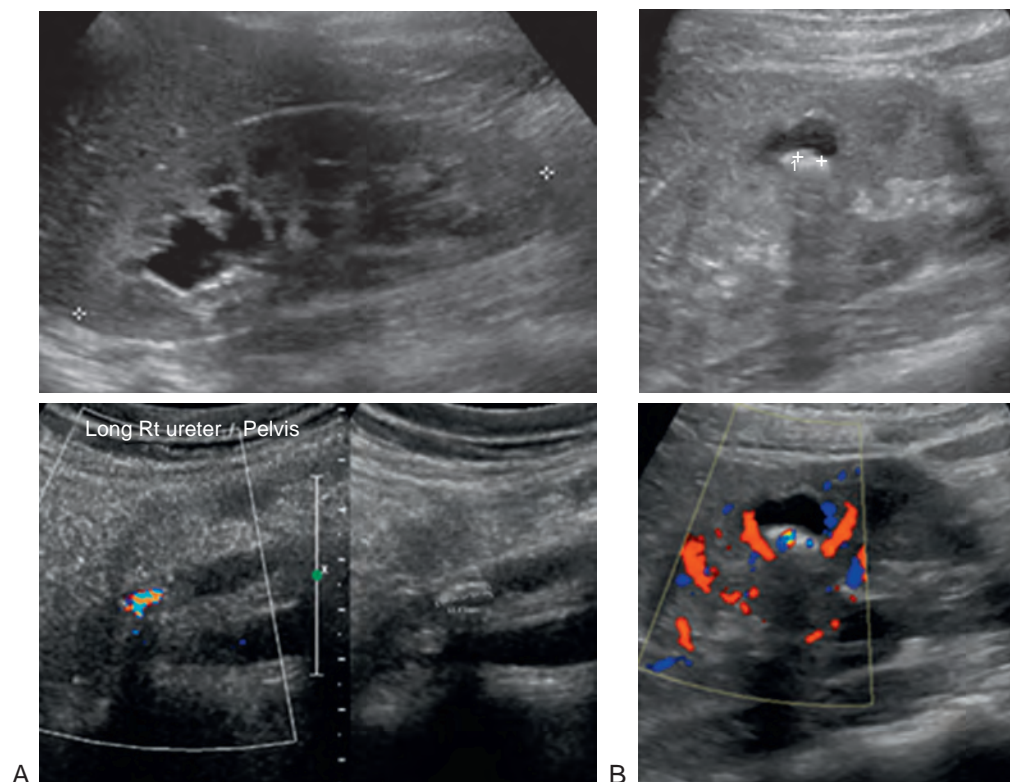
A, Renal sonogram demonstrating hydronephrosis and hydroureter associated with a mid-ureteral calculus. B, “Twinkling” artifact seen by color Doppler application to a renal calculus.
